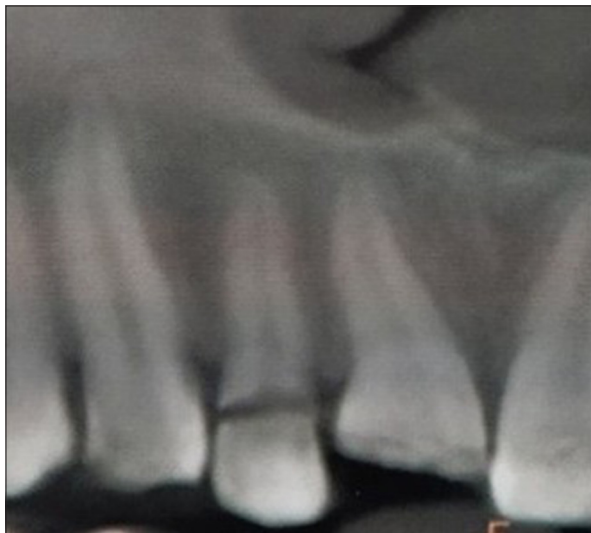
Radiograph showing Ellis Class 3 fracture # 11.
